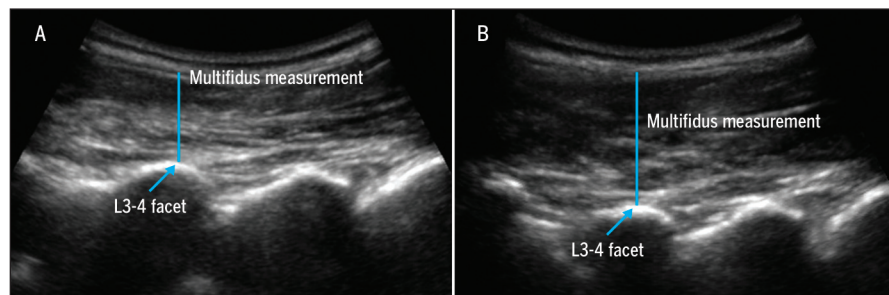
Ultrasound images of the multifidus (A) at rest and (B) during contraction.
